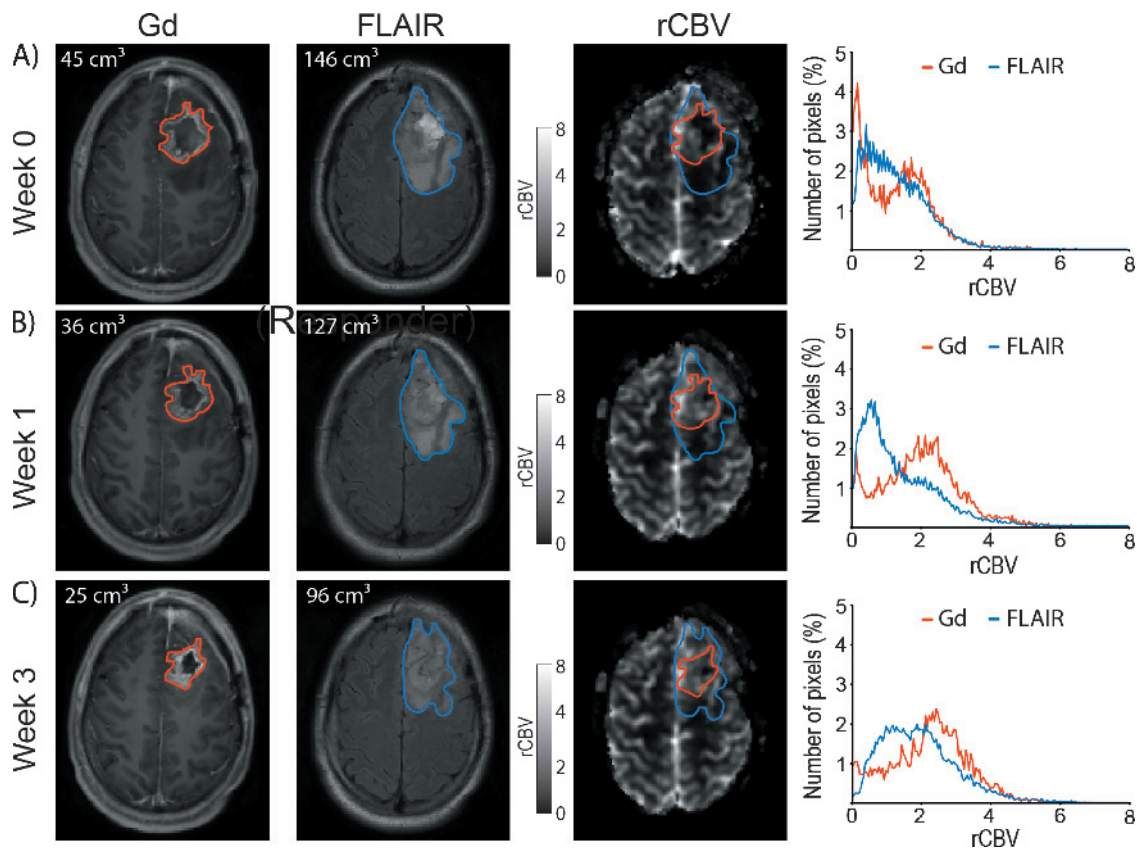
Representative T1-weighted post-Gd (left), FLAIR (middle), and rCBV maps (right) of a patient with glioblastoma at -1 (A), 1 (B), and 3 weeks (C) post-treatment initiation. Red and blue contours depict post-Gd T1-weighted and FLAIR imaging tumor volumes, respectively. The tumor histogram for rCBV is depicted using either Gd-VOI (red curves) or FLAIR-VOI (blue curves) obtained -1 (A), 1 (B), or 3 weeks (C) after treatment initiation.
